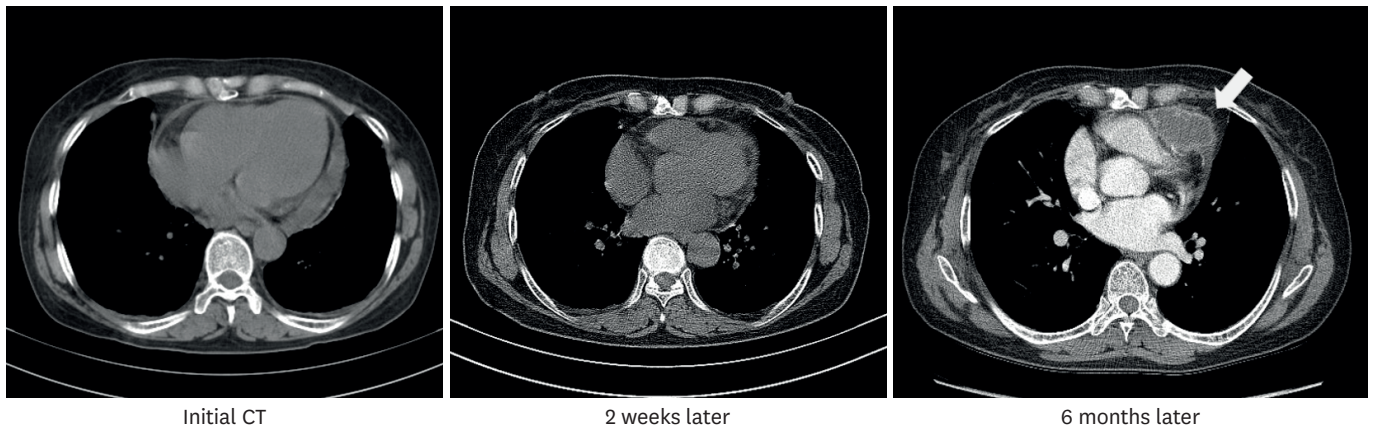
Serial changes on computed tomography. Pericardial effusion decreased without producing symptoms and slowly progressed to pericardial abscess (arrow).
